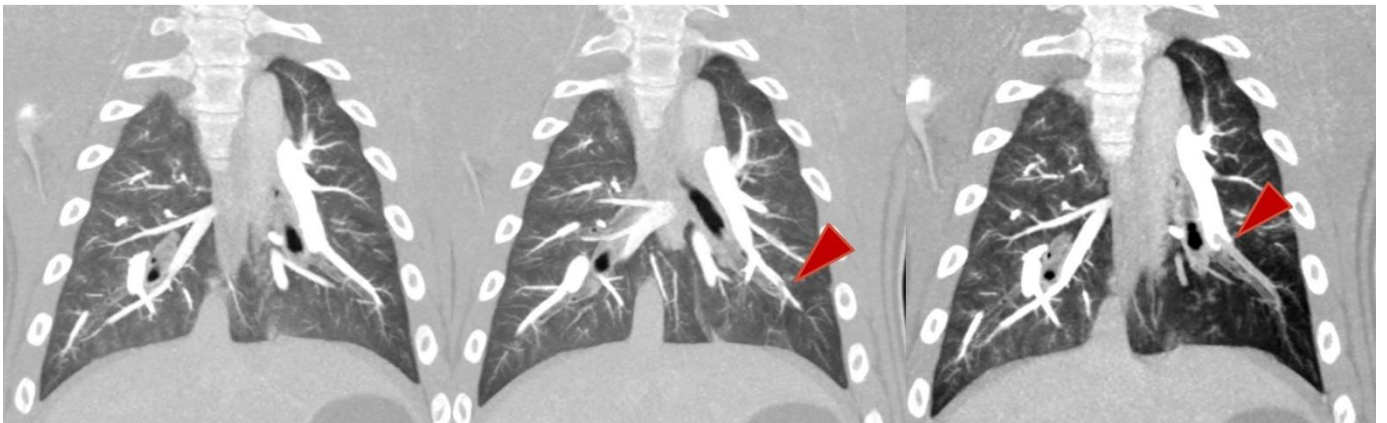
CT pulmonary angiography with the presence of small embolus.
